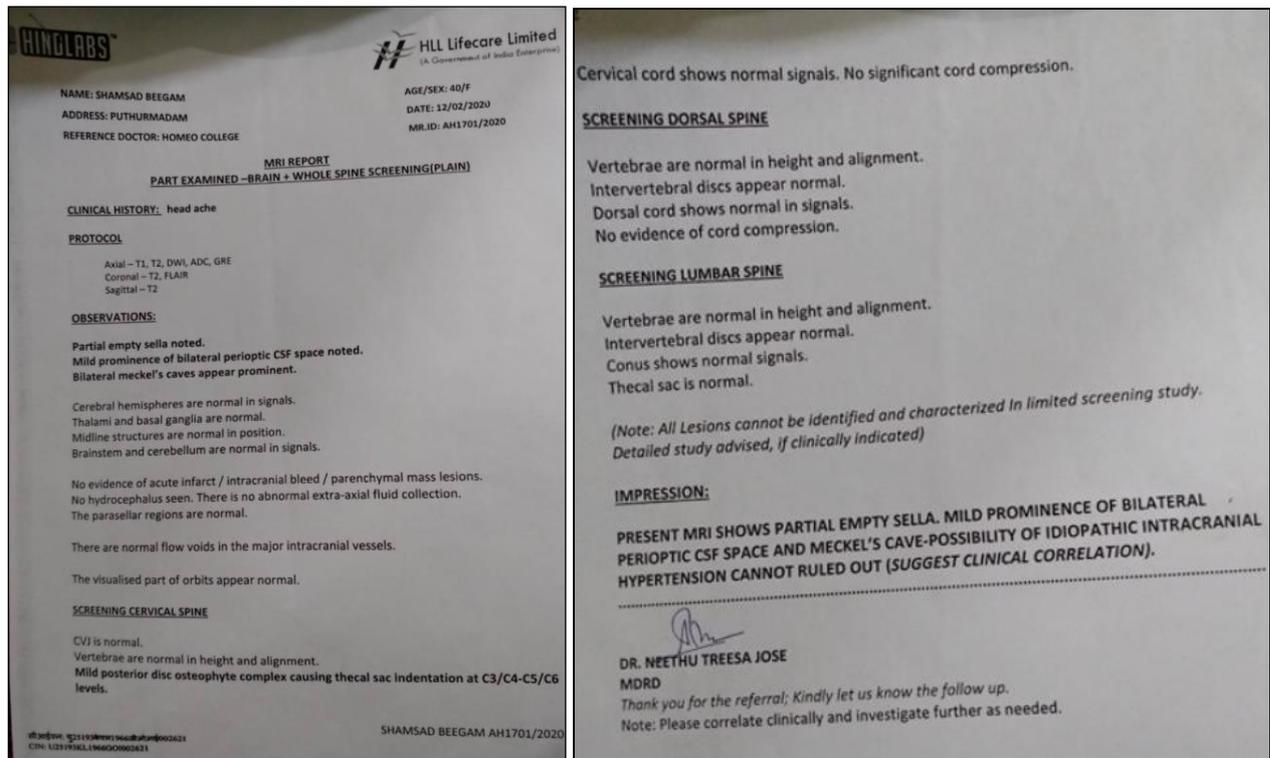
MRI:- Brain + whole spine screening (plain)
